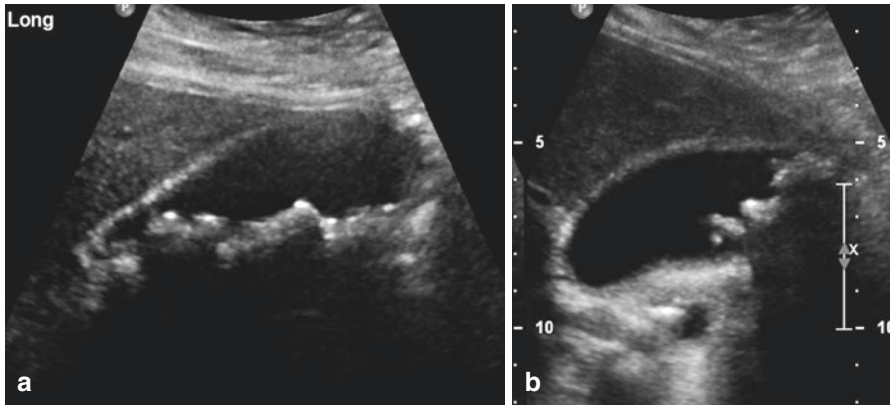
An ultrasound in a 62-year-old woman presenting with recurrent biliary colic with five episodes in the last month. (a) Supine study shows multiple stones in the gallbladder. The gallbladder wall is not thickened or contracted. (b) Erect study reveals all the stones are mobile with no stones in the region of the gallbladder neck
